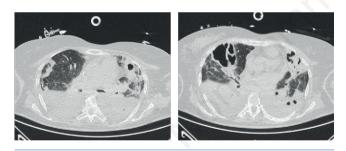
Lung CT scan showing bilateral dorsal consolidated tissue and pleural effusion, ground-glass opacities, an image of consolidation in the Right Middle Lobe (RML) with an abscessual cavity, together with a contralateral cavity in the lingula.
